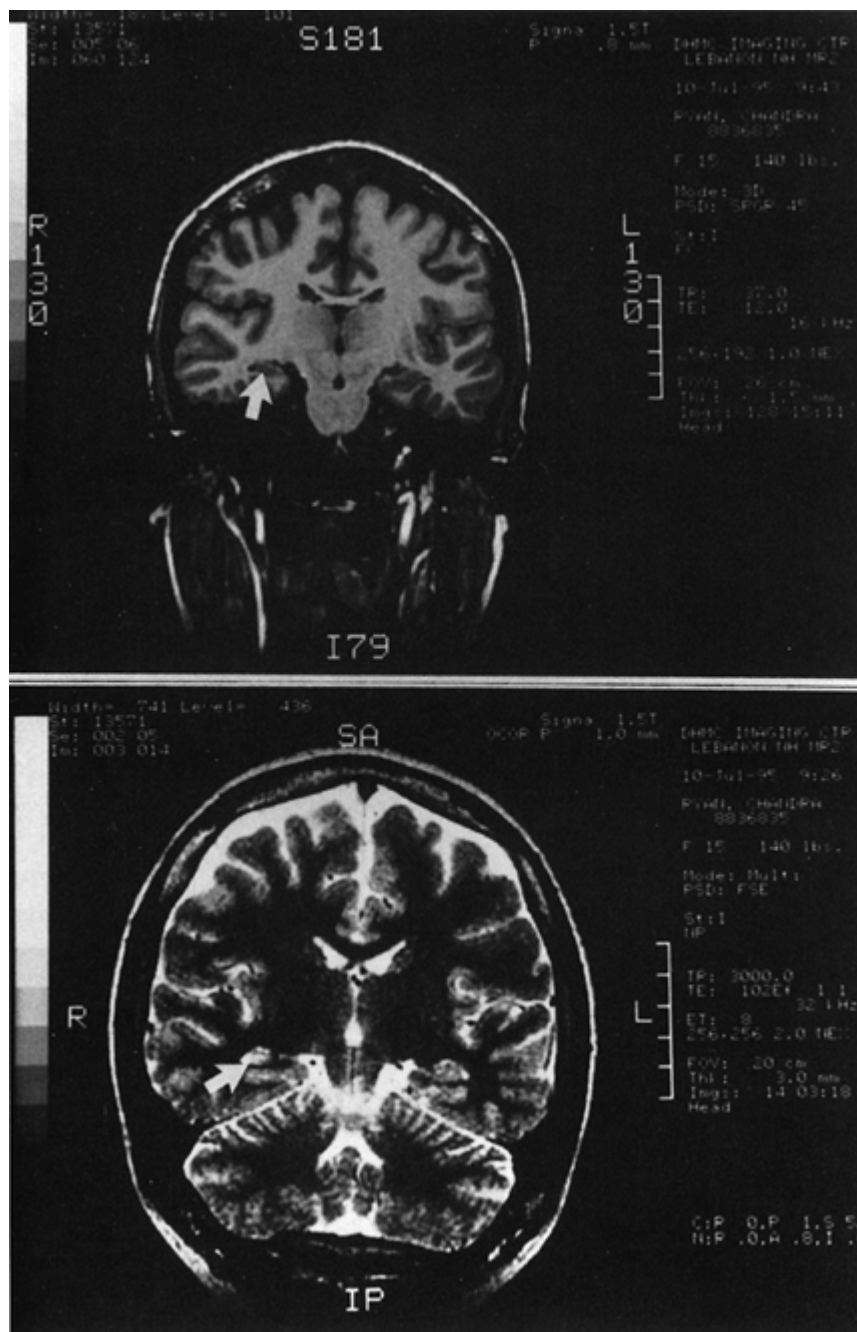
Patient No. 3. SPGR sequence (*top*) and T₂-weighted MRI (*bottom*) showing atrophy of right hippocampus and signal enhancement (*arrows*).
